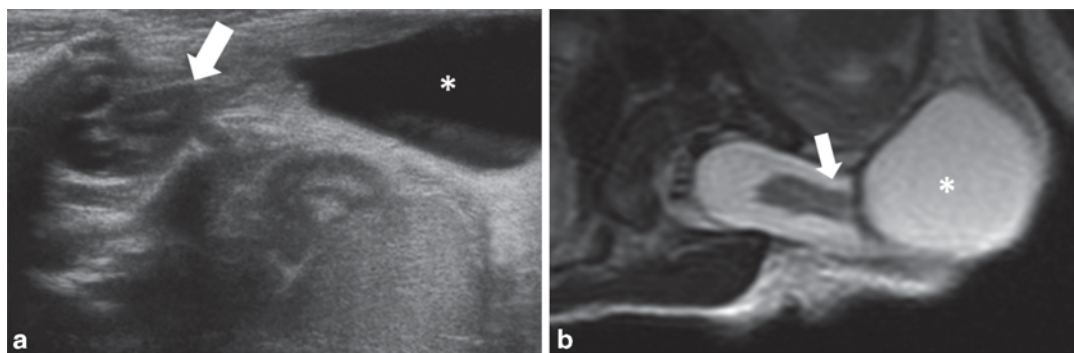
Myelomeningocele. Axial ultrasound (a) and axial T2 MRI weighted image (b). The neural placode
